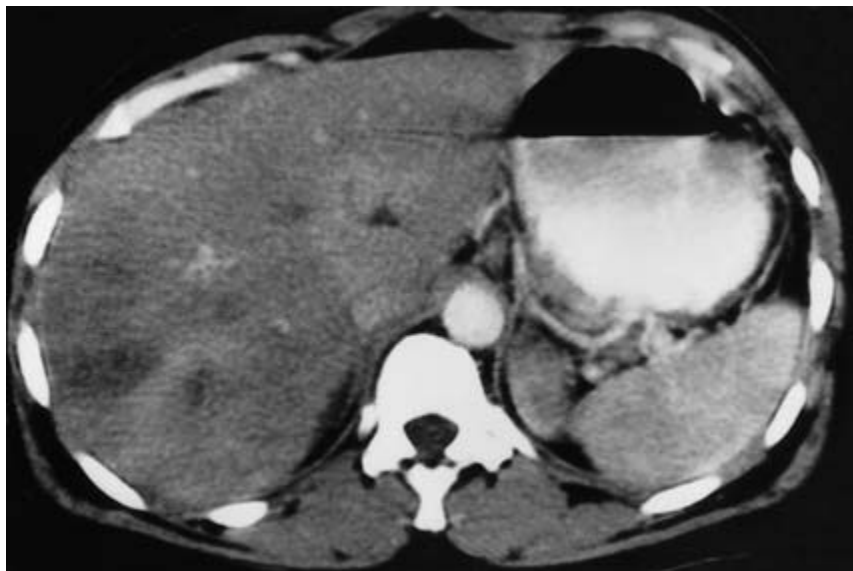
Fasciola hepatica*. CT in the migratory stage shows multiple, sometimes linear, filling defects at the periphery of the liver. (Courtesy of P.A. McCormick.)
